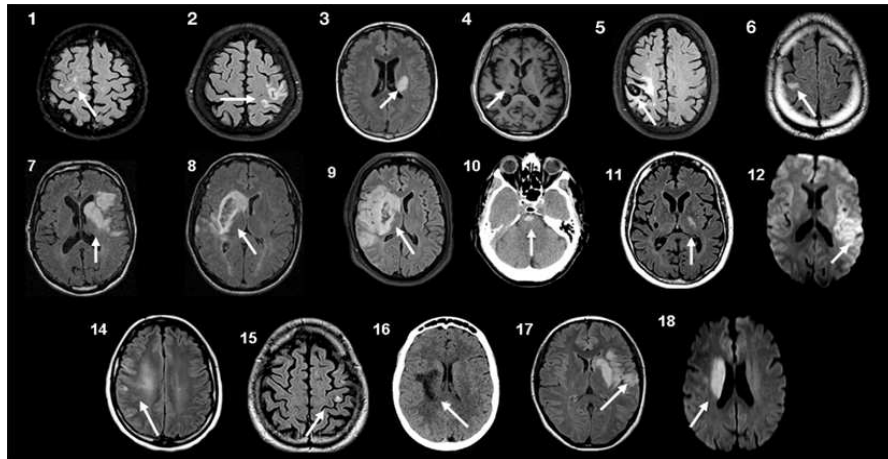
Brain imaging Magnetic resonance imaging (MRI) or computed tomography (CT) scans at the level of the stroke for each patient. Patients 10 and 16 had CT scans, patient 4 had a T₁-weighted MRI, patients 12 and 18 had Diffusion-Weighted Imaging (DWI), and all others had FLAIR T₂-weighted MRI. Patients 4 and 5 had an intracerebral haemorrhage. Patients 8 and 9 had a slight secondary haemorrhagic transformation. Patients 1, 15 and 17 had at least one other lesion compatible with a previous, minor stroke. Patient 6 had associated leukoaraiosis and small chronic subcortical infarcts. Patient 4 had small chronic subcortical lacunar infarcts. For patient 13, the MRI scans were not retained in the patient's medical folder, but a detailed neuroradiological report permitted localisation of the lesion (Table 3.1).
